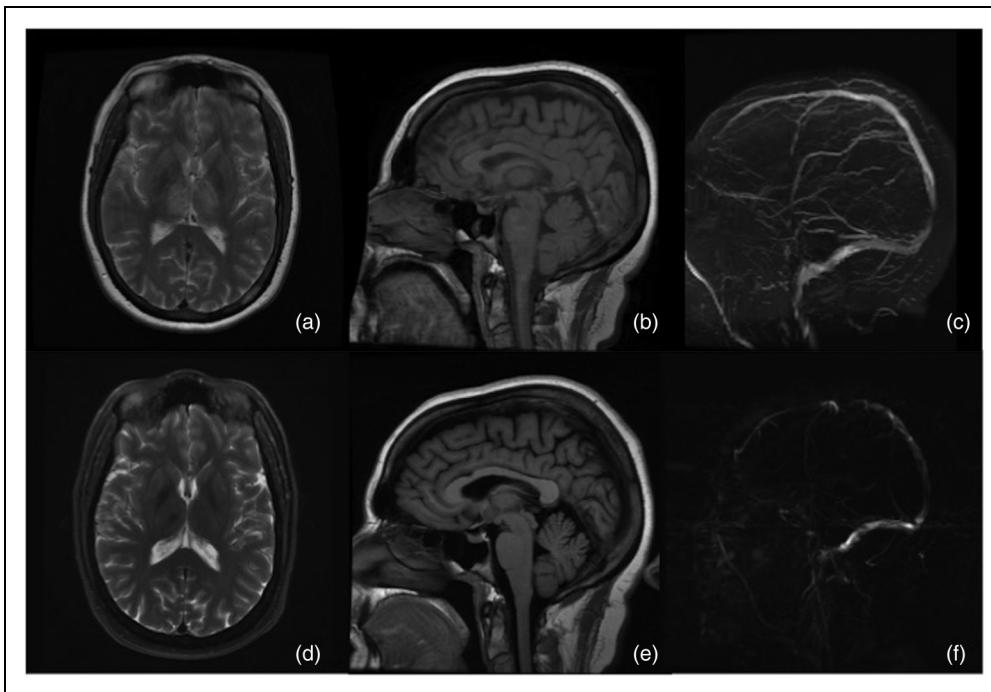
A 36-year-old female presenting with headache found to have CVT involving the deep venous system, straight sinus, left transverse sinus, left sigmoid sinus, and left internal jugular vein who underwent alteplase infusions via microcatheters positioned in the straight sinus, left transverse sinus, and left sigmoid sinus for 3 days with significant recanalization. (a) Pre-treatment T2 MRI brain showing bilateral thalamic edema, (b) pre-treatment T1 FLAIR MRI brain showing hyperintense thrombi in the straight sinus and deep venous system, (c) pre-treatment MRA brain showing no signal in the straight sinus or deep venous system, (d) post-treatment T2 MRI brain showing improvement of bilateral thalamic edema, (e) post-treatment T1 FLAIR MRI brain showing resolution of hyperintense signal in the straight sinus and deep venous system, and (f) post-treatment MRA brain showing return of signal to the straight sinus and deep venous system. CVT: cerebral venous thrombosis.
